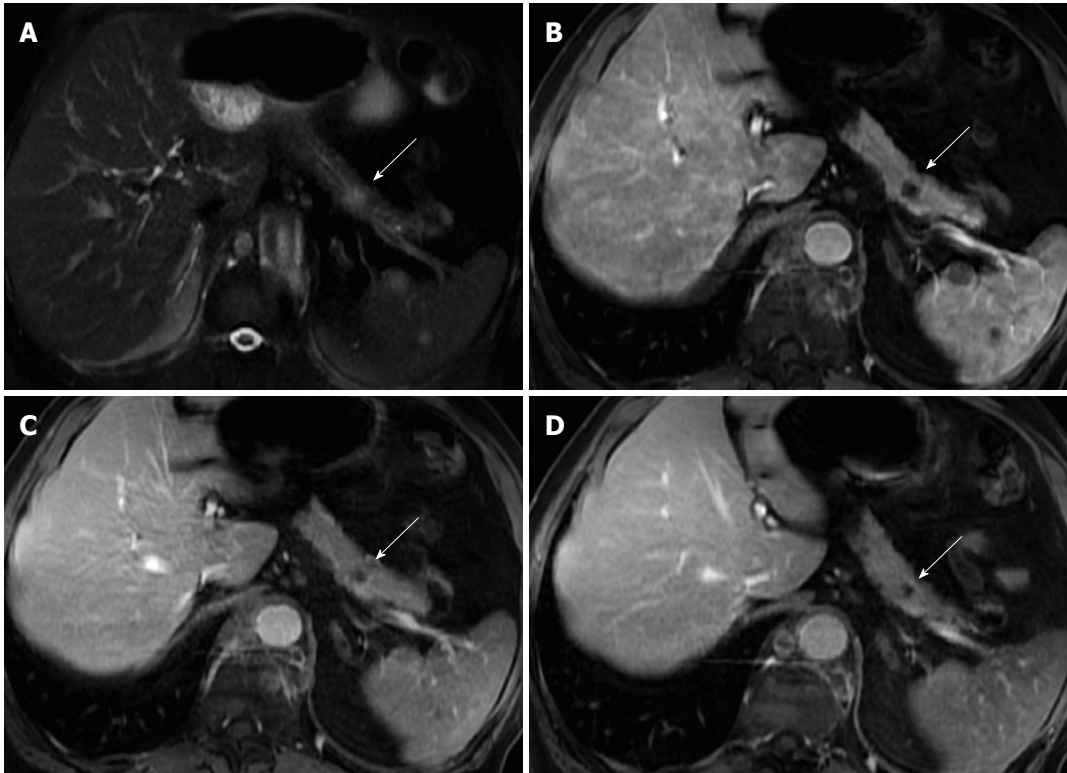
Solitary pancreatic metastasis. Axial T2-weighted SS-ETSE (A) and post-gadolinium fat-suppressed T1-weighted GRE images acquired in the arterial (B), venous (C) and interstitial (D) phases of enhancement. There is a nodular lesion in the pancreatic body showing moderate signal intensity on T2-weighted images (arrow, A) and showing hypovascular characteristics, with no pancreatic duct dilatation. These are typical features of a solitary pancreatic metastasis (arrows). Note additional splenic metastases (lung cancer). SS-ETSE: Single-shot echo train spin echo; GRE: Gradient echo.
